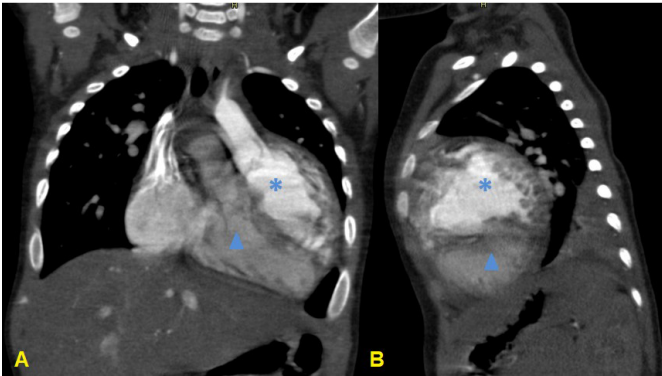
Computed tomography angiography: coronal (A) and sagittal (B) sections showing right ventricle in superior position and left ventricle (solid arrow) in inferior position.
